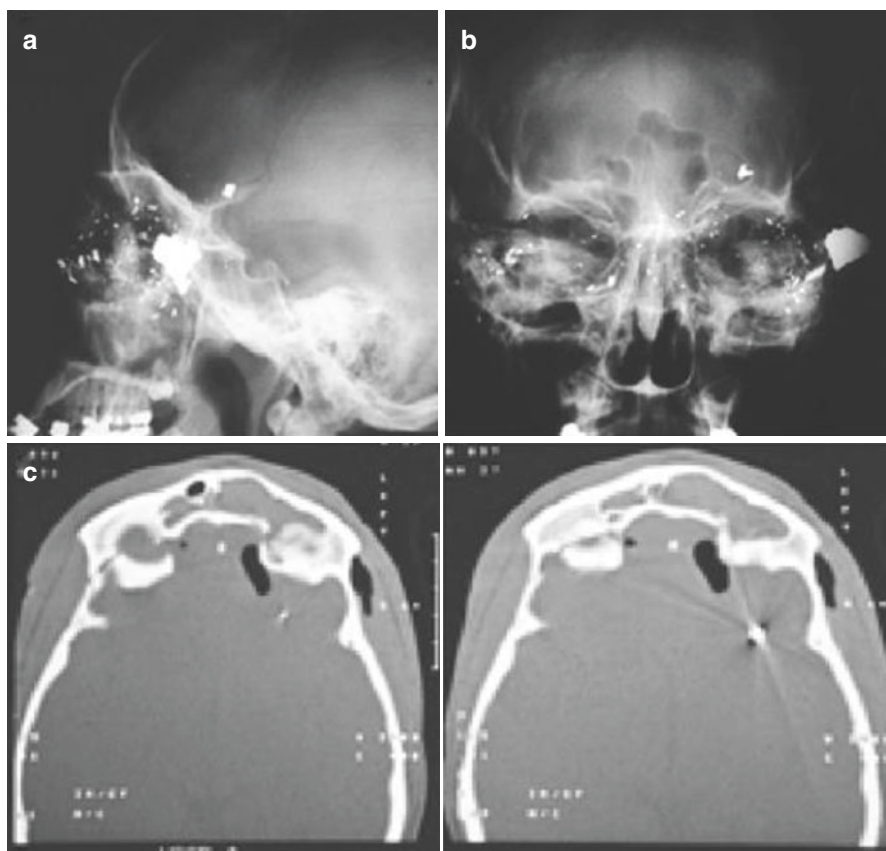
Lateral (a) and Anterior-Posterior (b) skull X-rays of GSW provides some information on retained fragments, presumed tract of injury, and involved structures. (c) CT scan demonstrates much better anatomic information in the same injury
